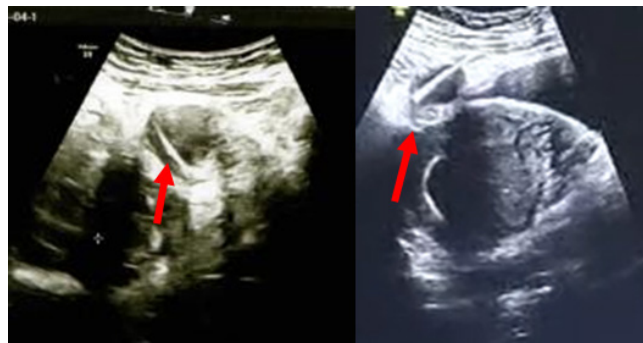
Transabdominal ultrasonography showing translocated intrauterine device (IUD) within a pocket containing fluid in the anterior of the uterus (Red line)
